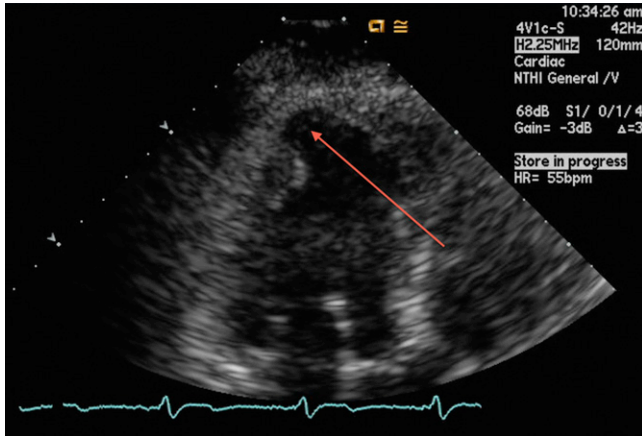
Transthoracic echocardiogram, apical long-axis view, demonstrating the apical aneurysm (arrow) characteristic of Chagas cardiomyopathy.
